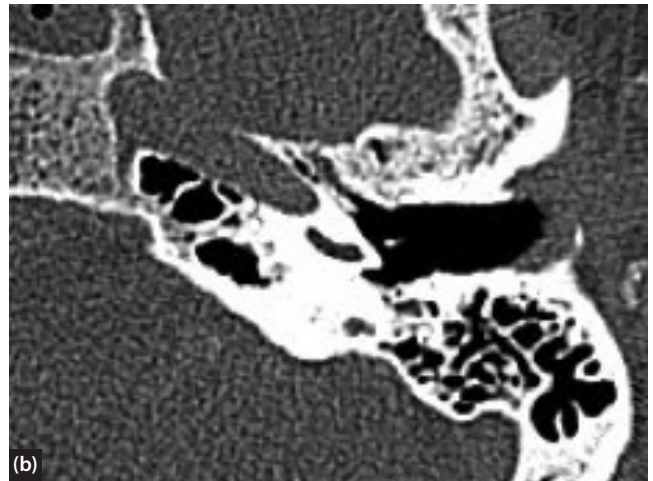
a and b Axial CT with thickened soft tissue in EAC, middle ear effusion and early subtle erosion of anterior epitympanum (arrow). Normal left middle ear for comparison.
